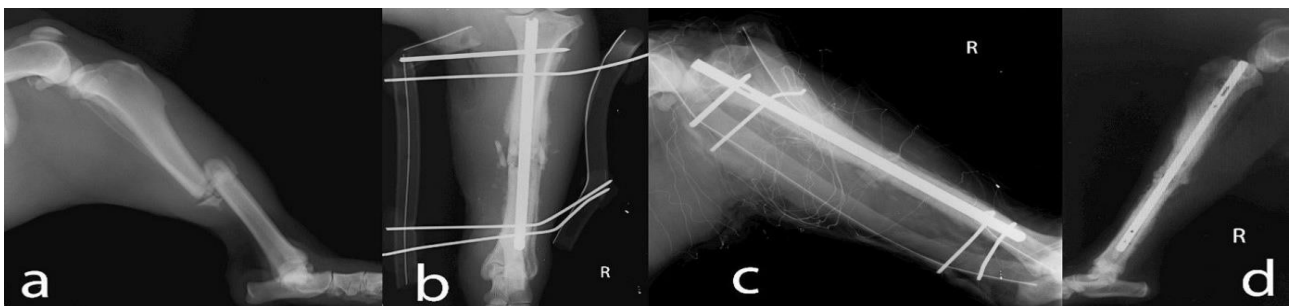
Preoperative and postoperative radiographs of case no 5. a. Preoperative, b and c. postoperative 30th day, d. postoperative 45th day radiographs after pins and external fixator removing of case 5.
